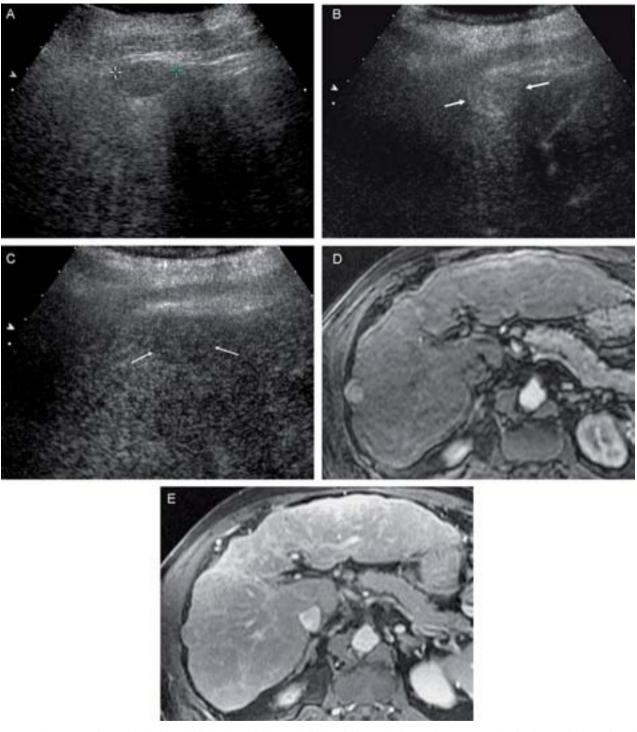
A 16-mm subcapsular HCC nodule in the right hepatic lobe with a typical vascular pattern that is observed in two imaging techniques. A) Hypoechoic nodule in the baseline ultrasound study (cursors). B) In the arterial phase, the CEUS confirms the hypervascular nature of the lesion (arrows). C) CEUS: washout in venous phase (arrows). D) The arterial phase of the dynamic MRI shows arterial uptake of the lesion. E) MRI: the venous phase shows contrast washout of the nodule.
